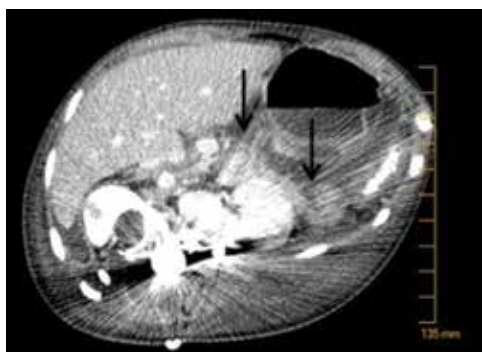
Abdomino-pelvic CT scan coronal view showing a Grade III pancreatic trauma with Wirsung duct disruption.
